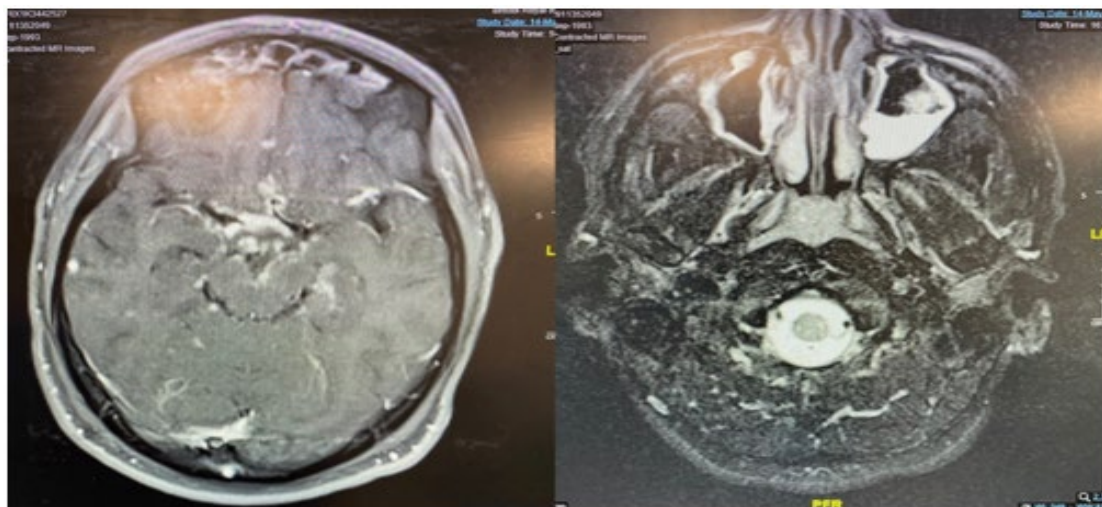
MRI /MRA brain imaging.
